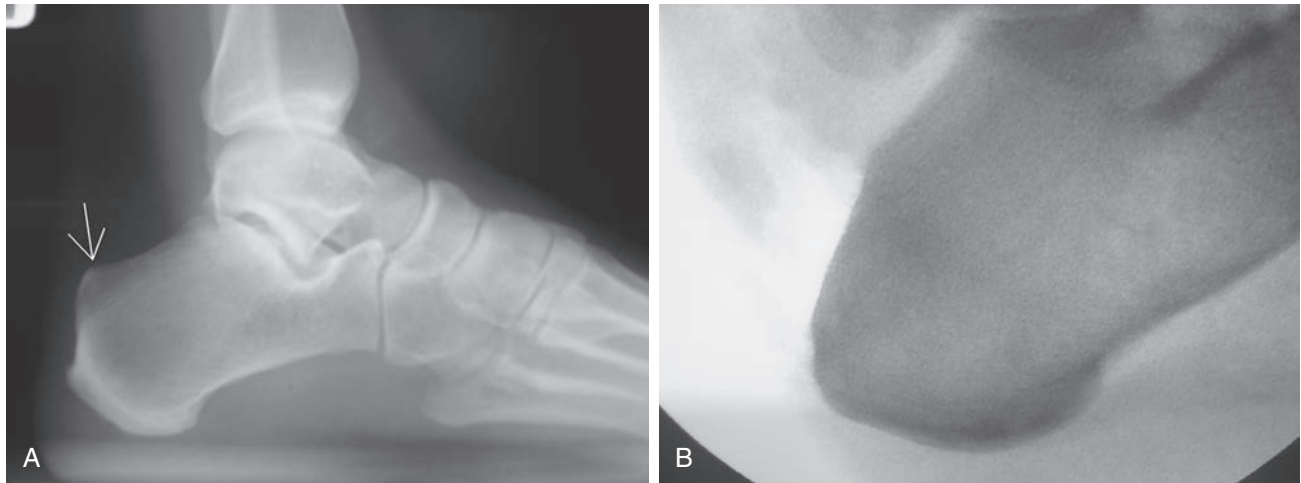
Haglund's Deformity in Dancers. (A) Preoperative lateral radiographic view and (B) intraoperative lateral fluoroscopic view after resection of the superior aspect of the posterior calcaneal tuberosity.
